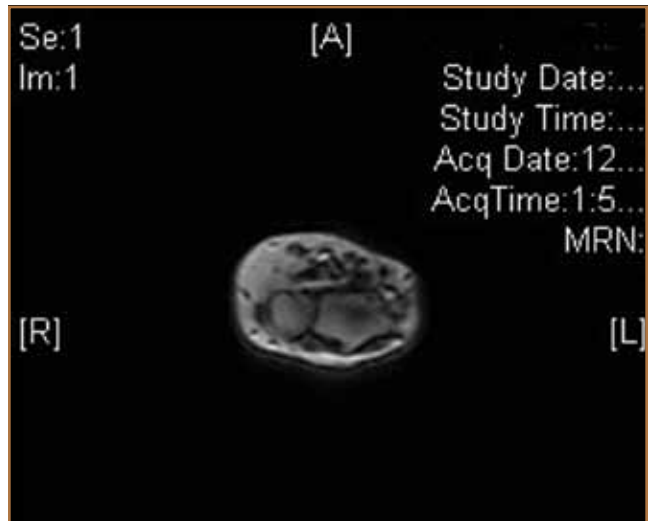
Scout MRI shows arm in over-the-head, Superman position.
